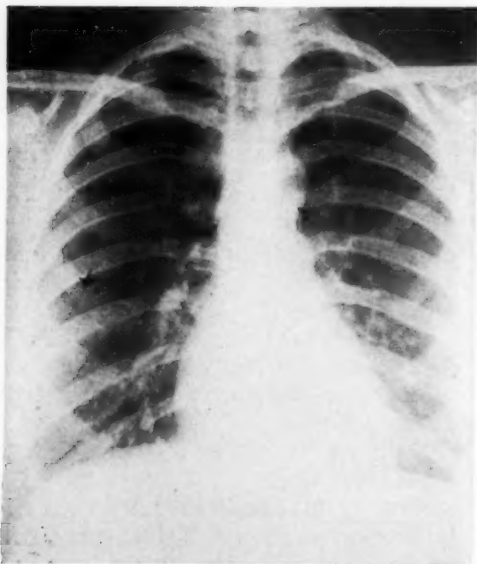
Chest roentgenogram of a normal, healthy adult. Arrows indicate the superior margin of each hilus and the visible portion of the minor septum.
